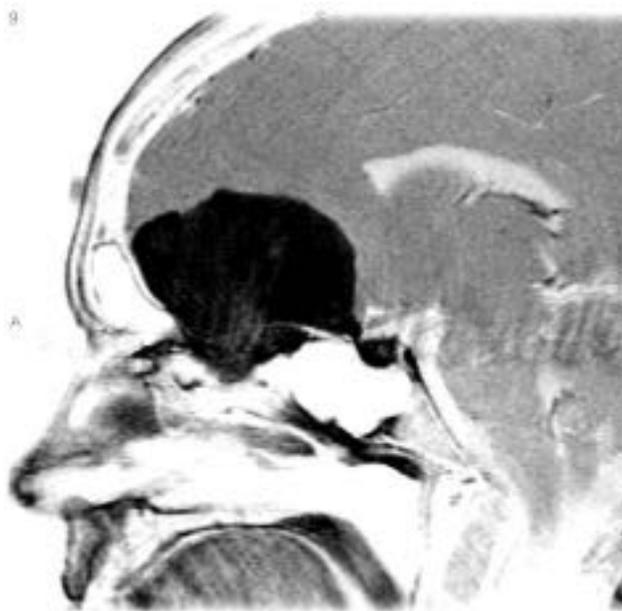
Sagittal postcontrast T1-weighted magnetic resonance images of a large olfactory groove meningioma extending from the back wall of the frontal sinus to the sella. Note the ethmoid sinus extension. Property of the Division of Neurosurgery, University of British Columbia. Used with permission.
